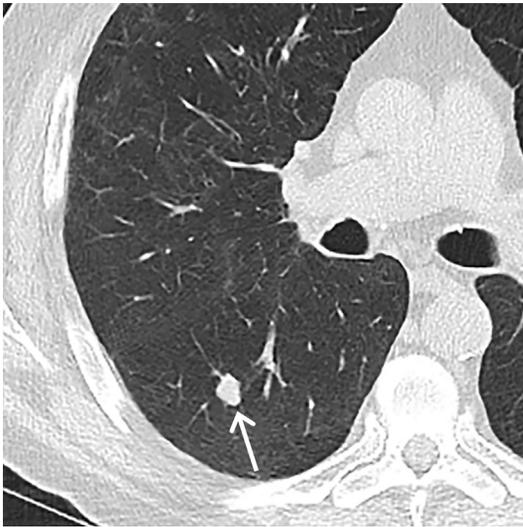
Baseline axial LDCT of a 64-year-old man demonstrates a 13-mm solid nodule (*arrow*) in the right lower lobe. Based on v1 of Lung-RADS, the examination was assigned an overall category of 4A, and 3-month LDCT and FDG-PET/CT were suggested as possible methods of further management. FDG-PET/CT (not shown) was subsequently performed and demonstrated increased FDG uptake within the nodule. CT-guided biopsy was then performed and revealed squamous cell carcinoma of the lung.
